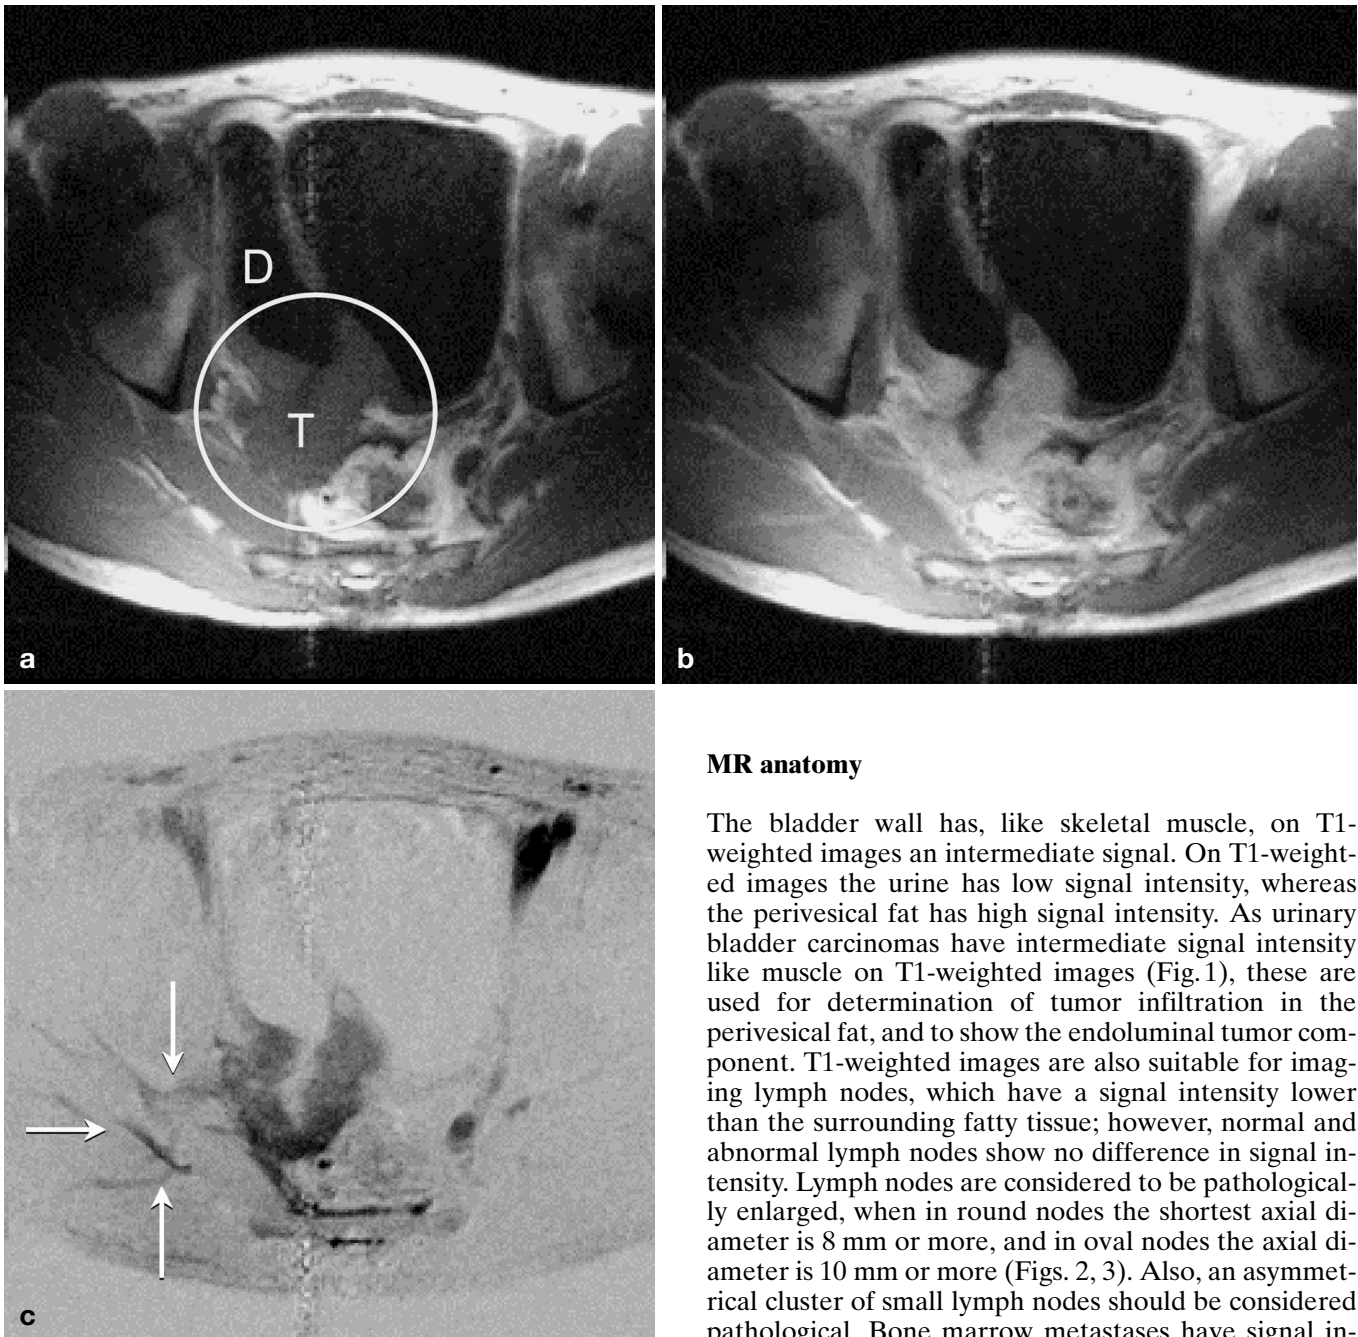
a–c. Patient with bladder diverticulum (*D*) and invasive cancer (stage T4B). a Axial T1-weighted GRE image shows tumor (*T*) extending into the perivesical fat (*circle*). b Same image 2 min post contrast injection shows more enhancement of tumor compared with wall. c Subtraction of a and b shows tumor enhancement in between pelvic muscles (*arrows*). This infiltration is not visible on T2-weighted images (see Fig. 4)
